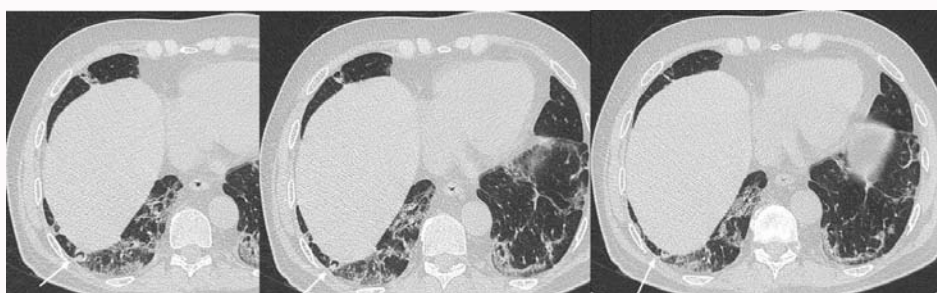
Axial thin-sections unenhanced CT scan show reticular thickening with symmetrical distribution and craniocaudal gradient. In right lower lobe we described concomitant centimetric excavated alterations (arrows).
